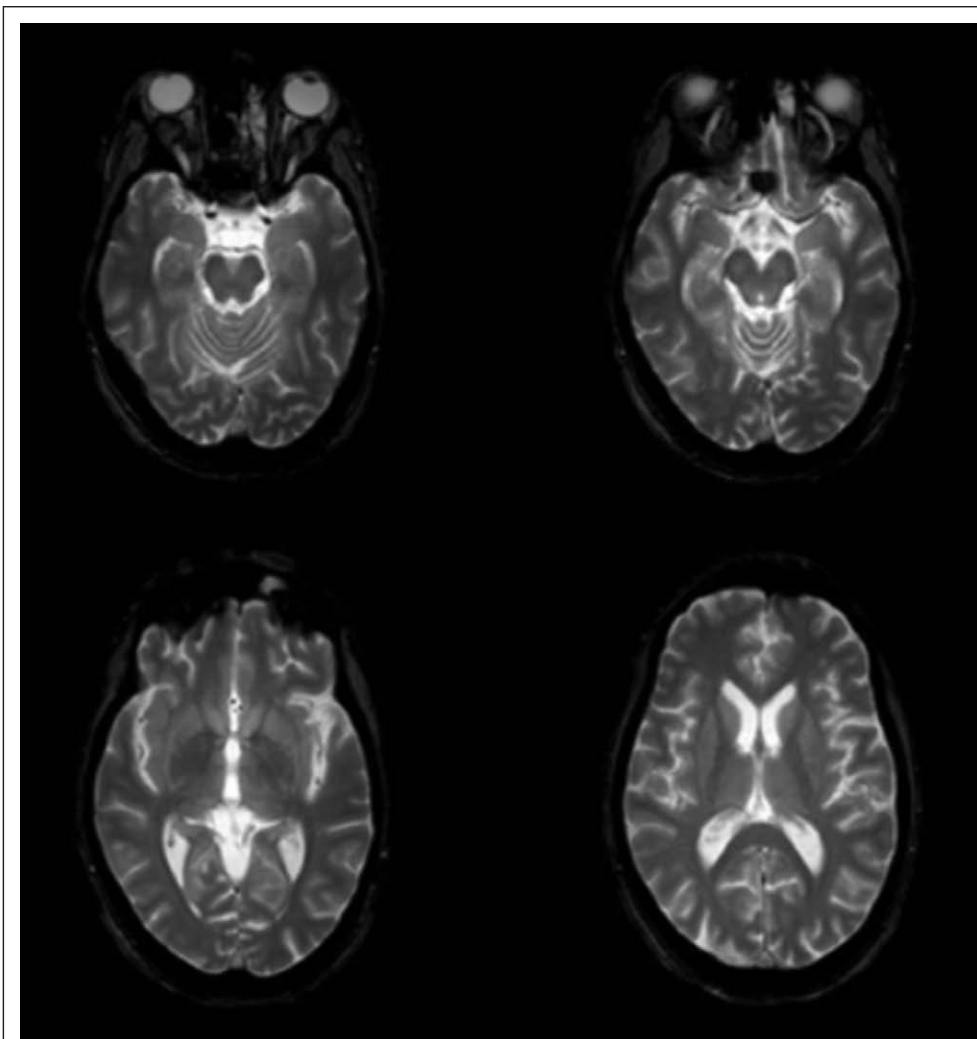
T2-weighted MRI sequence showing integrity of brain parenchyma and basal ganglia.
